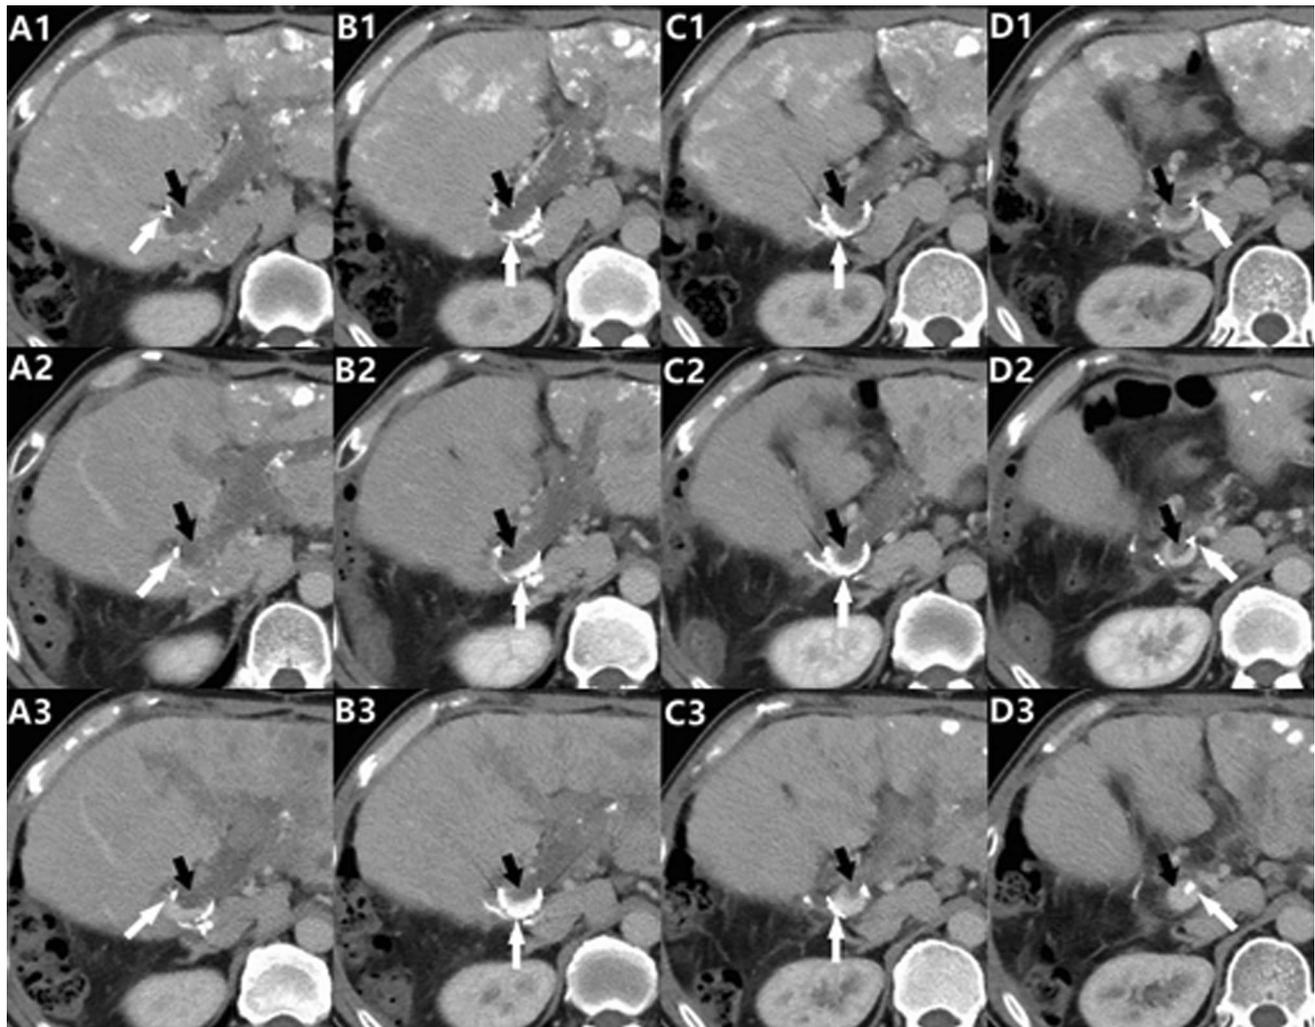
Contrast-enhanced CT of the helical I-125 seed implant in main portal vein (same patient as Fig. 2) showing the implant (white arrow) wrapped around main portal vein tumor thrombosis (black arrow) in a helical geometry. A1–D1) Enhanced CT 3 days after
